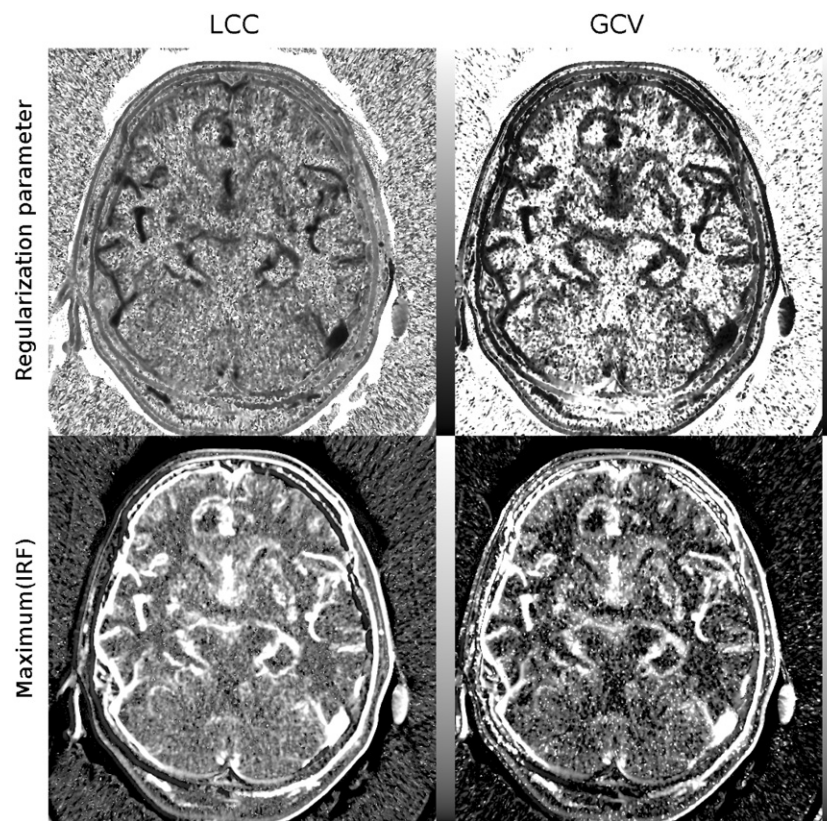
Maps of the regularization parameter (top row) and the maximum of the IRF (bottom row) calculated with the improved minimization of LCC (left column) and GCV (right column) on CT data of the brain. Grey scale ranges from 0.0 to 0.5 (top row) and from 0.0 to 0.05 ml ml⁻¹ s⁻¹ (bottom row). Note that both with LCC and GCV, underregularized solutions appear in the form of hyperintense pixels in the maps of the maximum in the IRF. The problem is more severe with GCV than with LCC.
